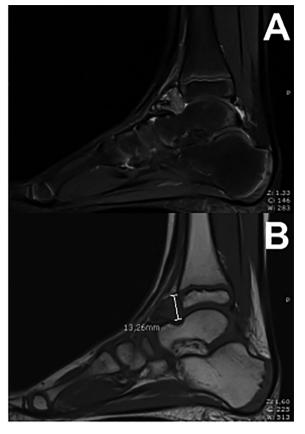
MRI shows a well circumcised lesion in the anterior recessus of the tibiotalar joint. A. Sagittal fat-suppressed proton-density-weighted turbo spin-echo sequence with a hyper-intense signal of the lesion. B. Sagittal T1-weighted turbo spin-echo sequence with a hypo-intense signal of the lesion.
